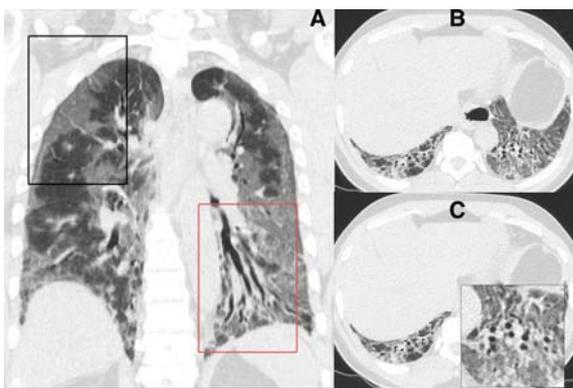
CT images of a 53-year-old male, who presented with a history of fever and shortness of breath for 1 week. He had high oxygen requirement at presentation with extensive peripheral ground glass changes (A- black box) and bibasal bronchial dilatation (B&C). The patient went on to be intubated and succumbed to the disease on day 28 of the presentation.
